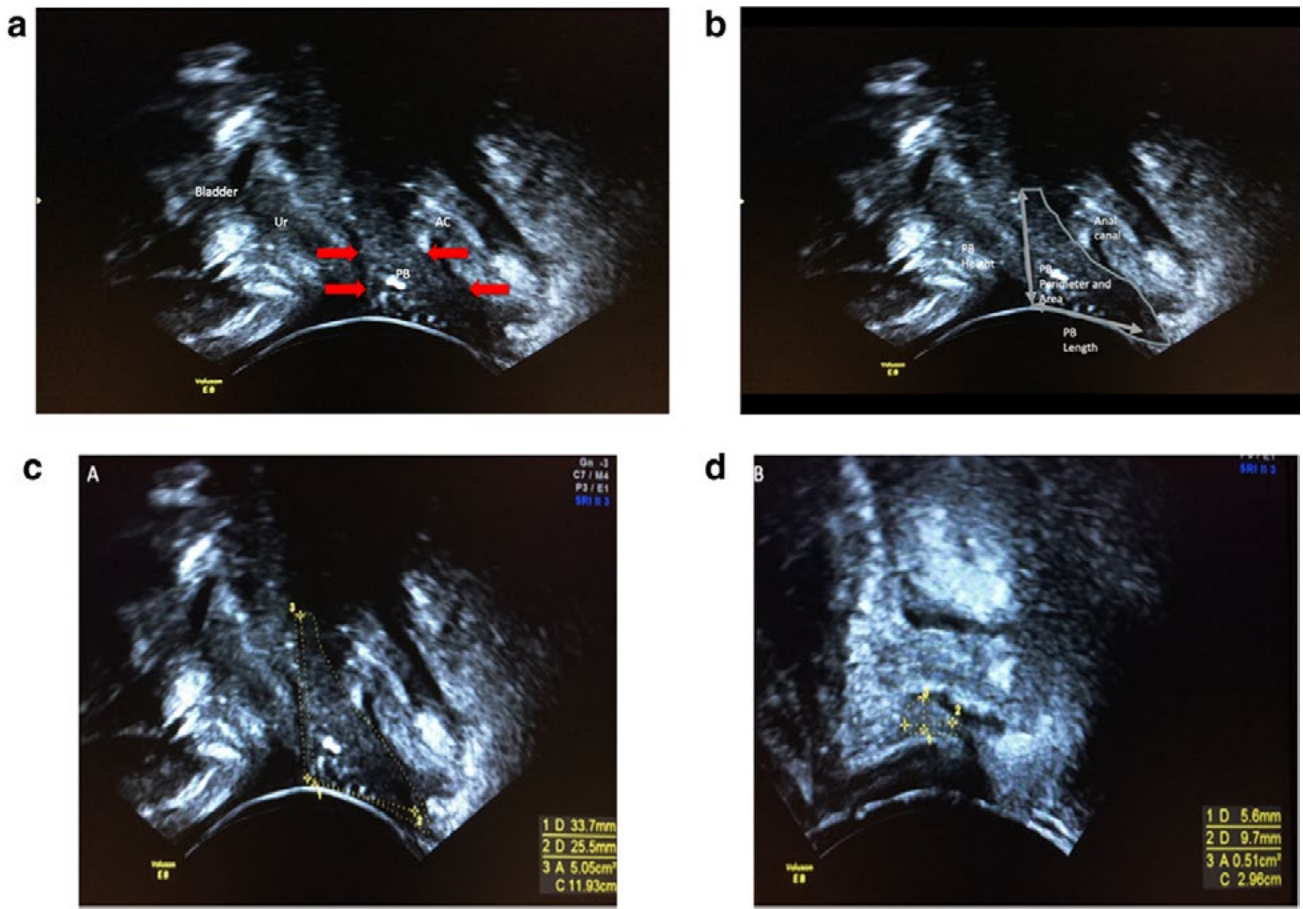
Perineal body on 2D midsagittal ultrasound. A. perineal body shown by the red arrows. B. perineal body width, length and perimeter demonstrated. C. perineal body measurements done on Voluson E8, showing area 11.93cm² that is derived from tracing the perimeter with the roller ball. D. small perineal body in the presence of a large rectocele showing area 2.96cm². (198)
